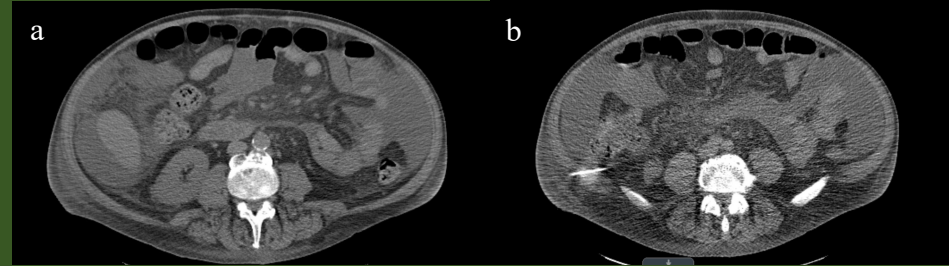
a) Axial CT image of right colon in close proximity to right kidney; b) Needle introduced for hydrodissection with D5W and pneumodissection with room air
